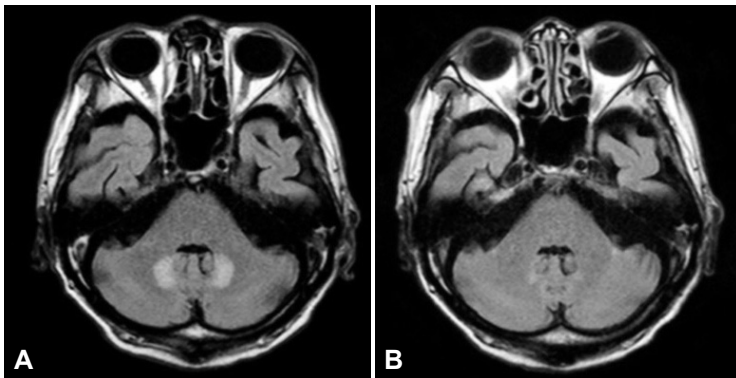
Brain MRI images before and after metronidazole discontinuation. A: Axial fluid-attenuated inversion recovery (FLAIR) scan showing increased signal intensity in the bilateral dentate nuclei of the cerebellum. B: Complete resolution of the high signal intensity in the dentate nuclei at day 16 after metronidazole discontinuation.
